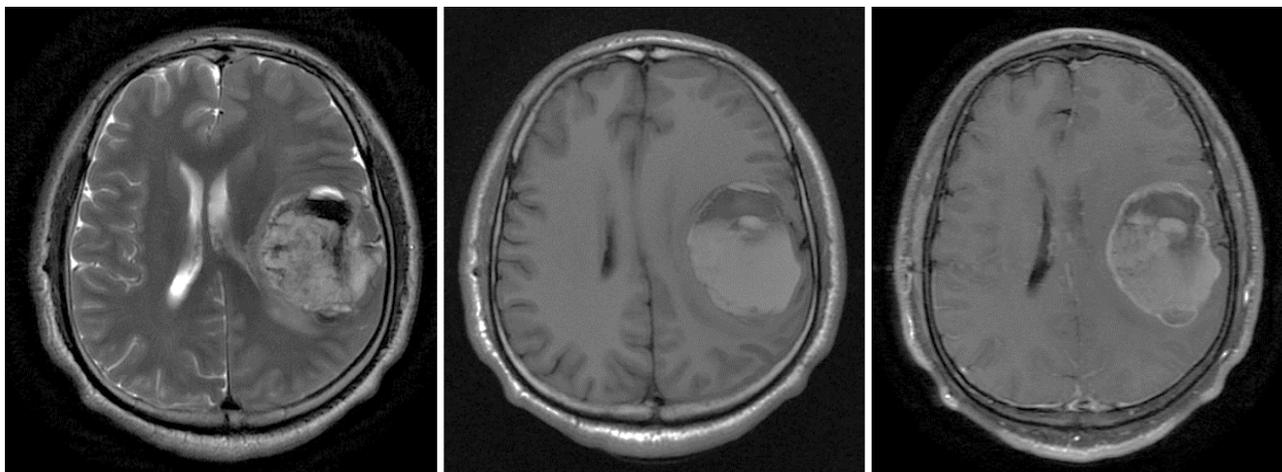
Preoperative magnetic resonance imaging. Round abnormal signal occupying lesions on T2-weighted imaging (WI) and T1WI were long or short mixed signals, associated with cystic and minimal edema. The wall and substantial part of the lesion were enhanced.
